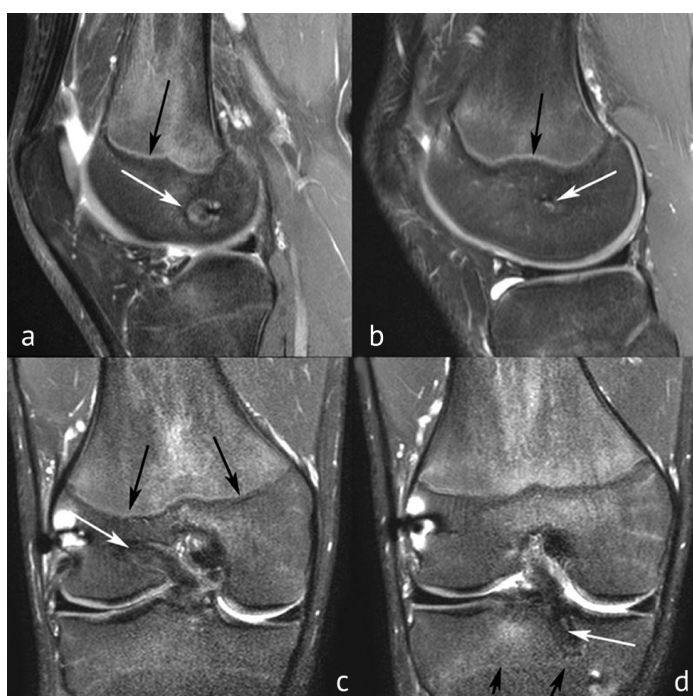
MRI sagittal view of the knee joint (a and b) at 12-month follow-up showing the location of the canal in the lateral condyle of the femur (white arrows) relative to the growth plate (black arrows). MRI coronal view (c and d) shows the location of the canals in the femur and tibia (white arrows) relative to the growth plates (black arrows)
